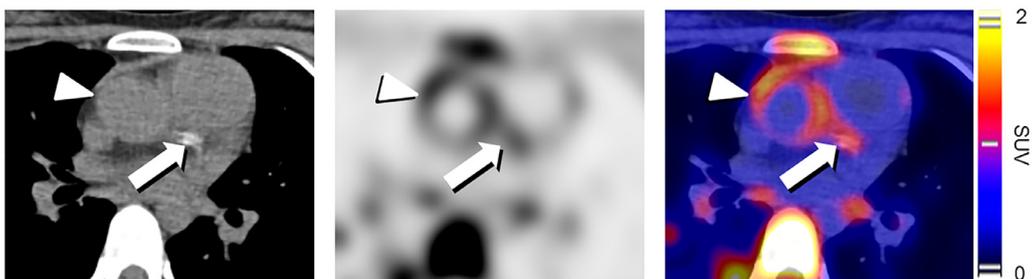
Selected CT (left), FDG PET (middle), and fused (right) transaxial images of a FDG-PET/CT study performed in a 26 y-o female with history of Takayasu arteritis with aortic and coronary involvement and stenting of the left main artery 1 year prior to the study. The study was performed following a myocardial suppression protocol including prolonged fasting, high-lipid low-carbohydrate diet, and intravenous heparin injection. Increased uptake is seen in the ascending aorta (arrowheads) as well as in the left main artery (arrow), corresponding to the stent. Uptake in the ascending aorta is compatible with aortitis. Subsequent angiography showed a 50% intra-stent stenosis extending in the circumflex artery.
